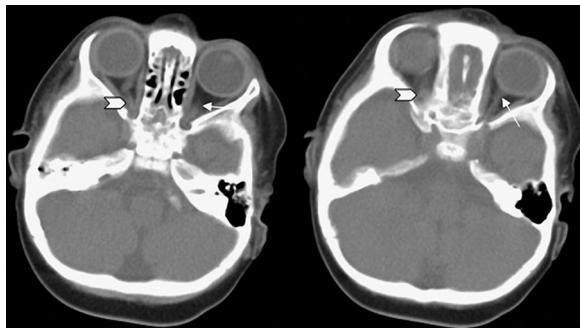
Axial non-contrast CT images of the brain showing reduced caliber of the left optic nerve (arrow) as compared to the right (arrowhead).
